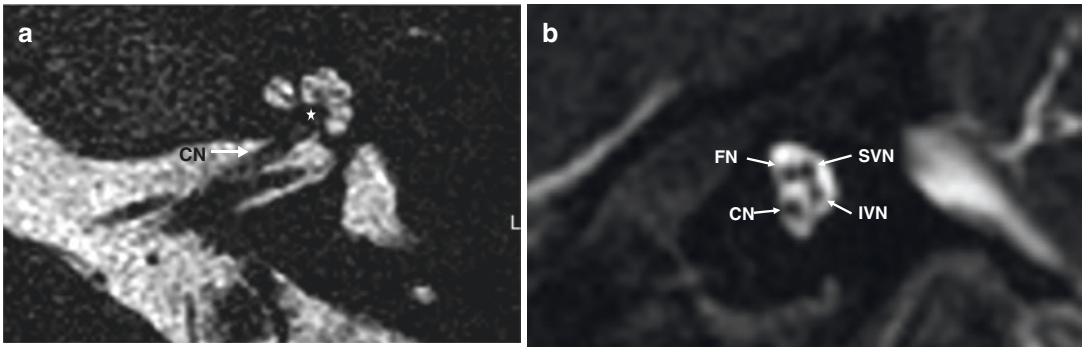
Magnetic resonance imaging of cochlea and cochlear nerve. (a) Axial section (CN = cochlear nerve, white star = modiolus). (b) Parasagittal section perpendicular to the IAC (CN = cochlear nerve, FN = facial nerve, SVN = superior vestibular nerve, IVN = inferior vestibular nerve)
